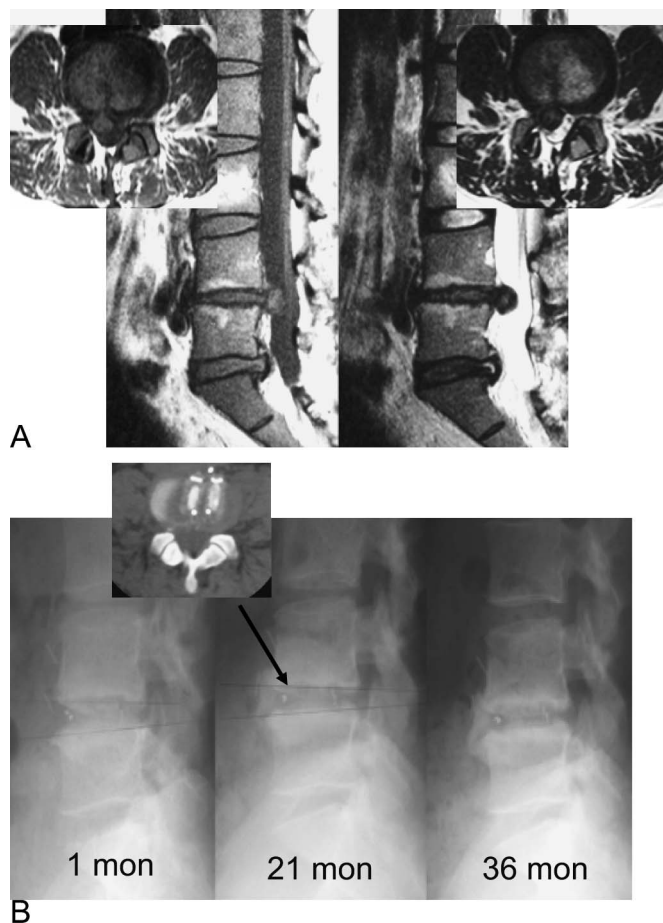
A, Spinal MRI revealing a recurrent disc herniation with degenerative disc change at L4–L5: left (T1-weighted image) and right (T2-weighted image). B, Series of post-operative radiographs demonstrate solid fusion. No evidence of adjacent segment degeneration is noted on the radiograph obtained 36 months after surgery.
